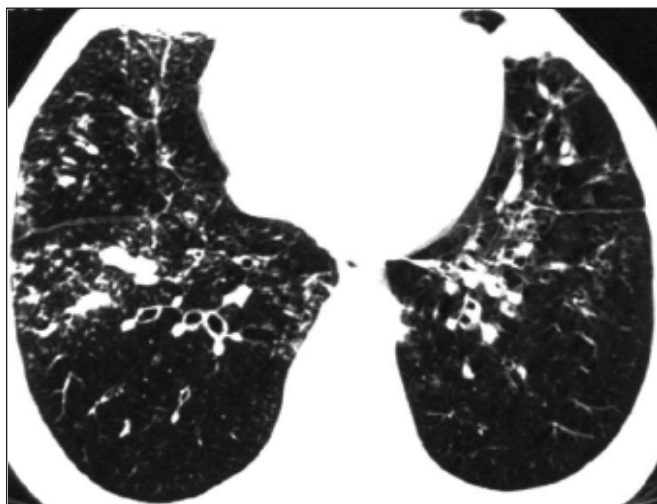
HRCT scan image of a patient with mucoid impaction and bronchial wall-thickening
